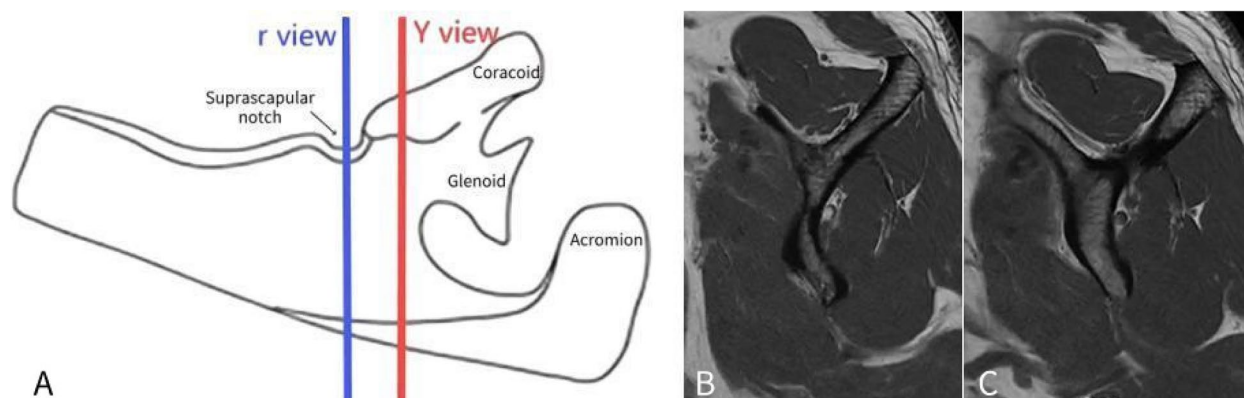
A Overhead view of the two different sections (r view and Y view in this study) at the scapular position, with the r view at the suprascapular notch position and the Y view at the most lateral aspect where the scapular spine was in contact with the scapular body. B MRI of the shoulder joint T1-weighted sagittal section of the suprascapular notch (r view). C MRI of the shoulder joint T1-weighted sagittal section of the scapular Y view
